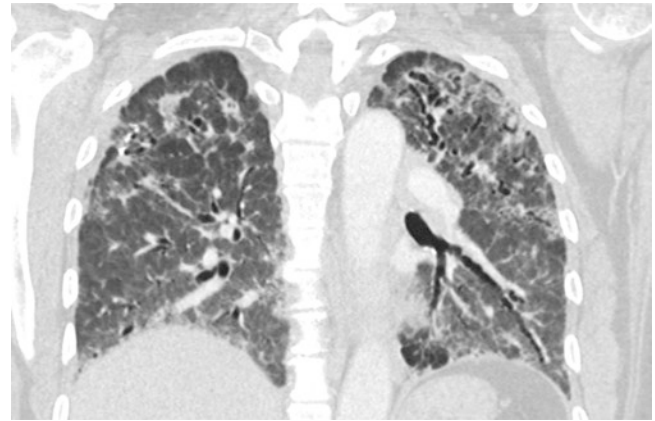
Coronal CT of NSIP showing bilateral, lower and upper lobe, symmetric ground-glass opacities with marked traction bronchiectasis
